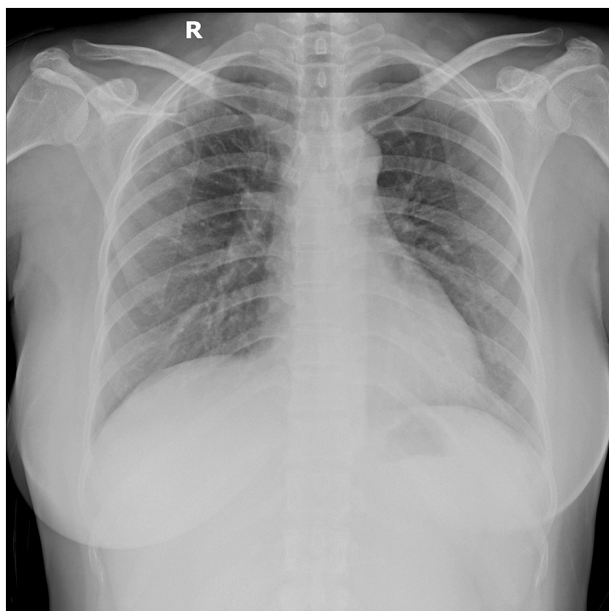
Chest X-ray taken at follow-up 17 days after discharge.
